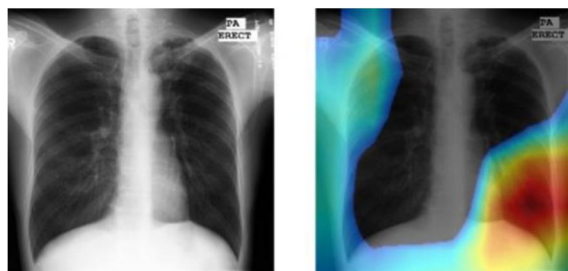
A test case using CAMs in the identification of aberrant X-rays, with an emphasis on the infected lung area.
